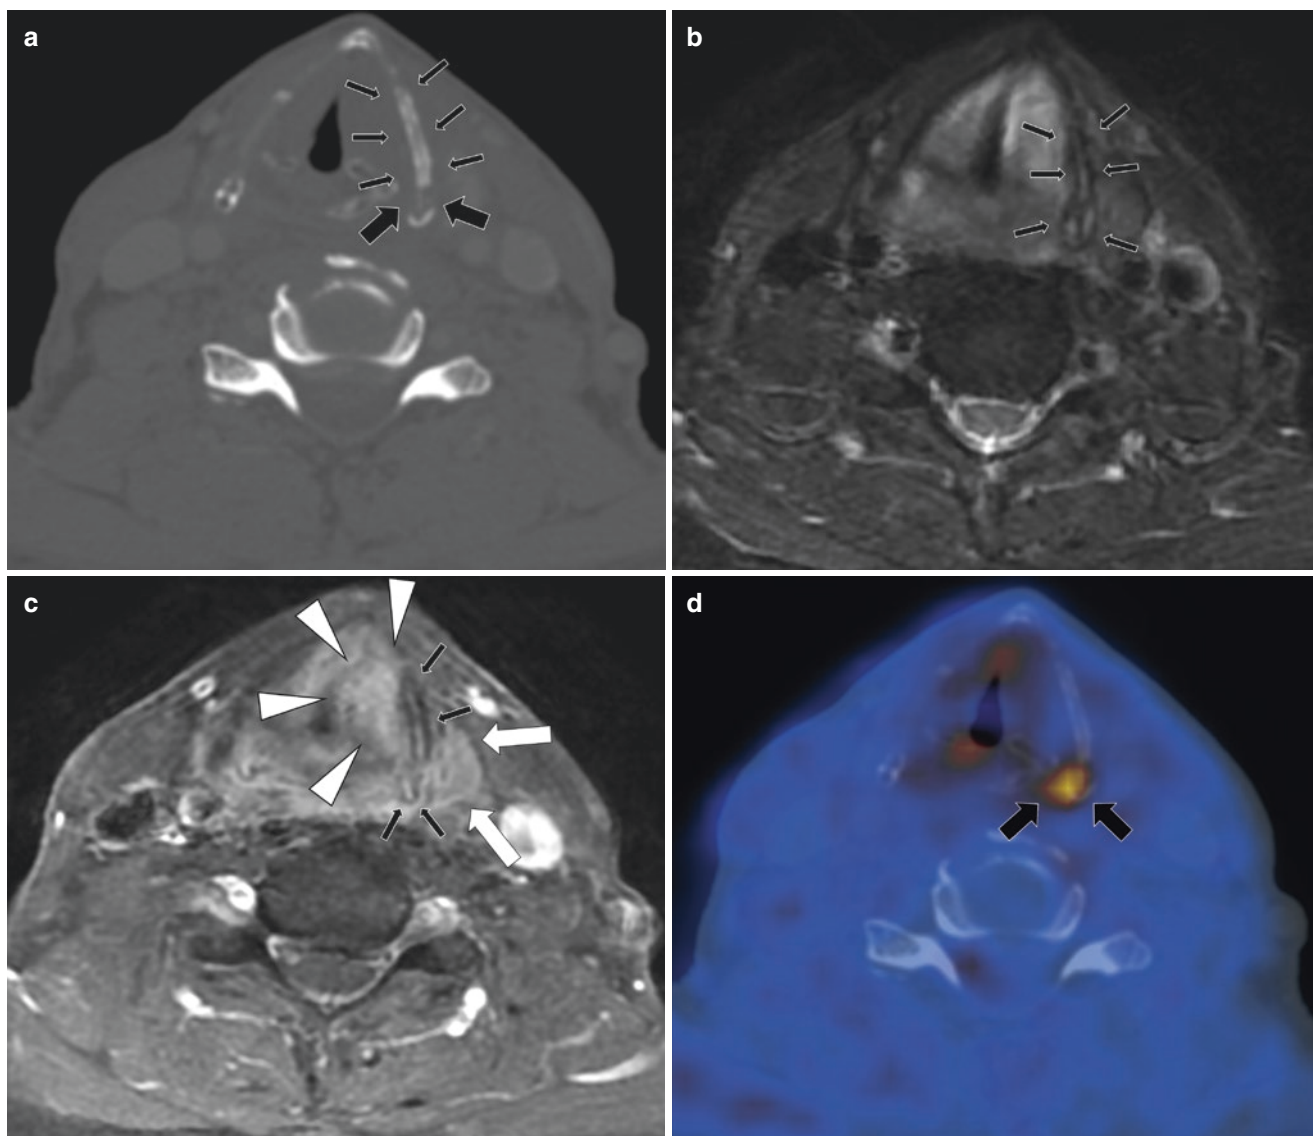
A 62-year-old man with supraglottic laryngeal SCC. Images were obtained 7 years after radiation therapy. CT showed an irregular calcification (a, thin arrows) and erosion (a, thick arrows) of the left thyroid cartilage lamina. Hyperintensity was noted on fat-sat T2WI (b, arrows) and on contrast-enhanced T1WI (c, thin arrows). Corresponding to the bone erosion on CT (a, thick arrows), fused PET images demonstrated focal uptake in the thyroid cartilage (d and e, arrows). This finding indicated potentially recurrent SCC with cartilage invasion.
